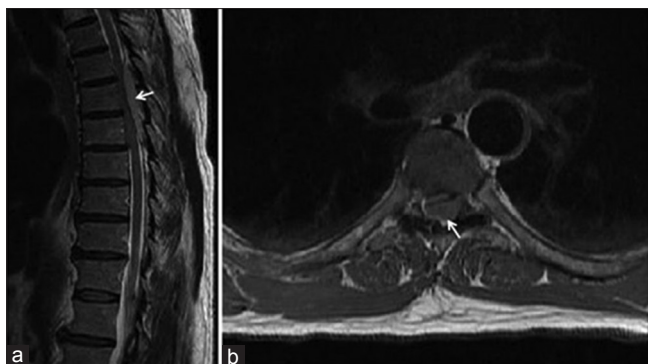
(a) Sagittal T2 MRI sequence shows a hypodense epidural mass (arrow) compressing the spinal cord from T5–T7. (b) Axial T2 MRI sequence shows a nonenhancing lesion isodense to soft tissue (arrow) causing severe spinal cord compression
